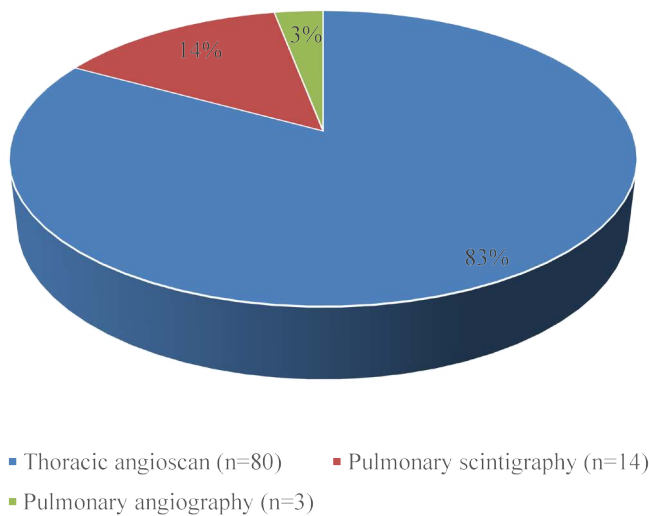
Medical imaging examination the most indicated to eliminate a pulmonary embolism in front of a thoracic pain with normal thoracic radiography.
